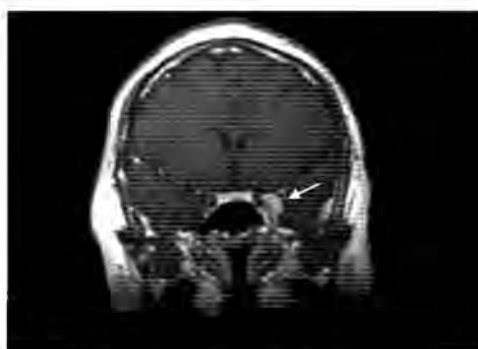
Coronal post-contrast T1 weighted MR image demonstrate enhancing mass adjacent to the left cavernous sinus.
